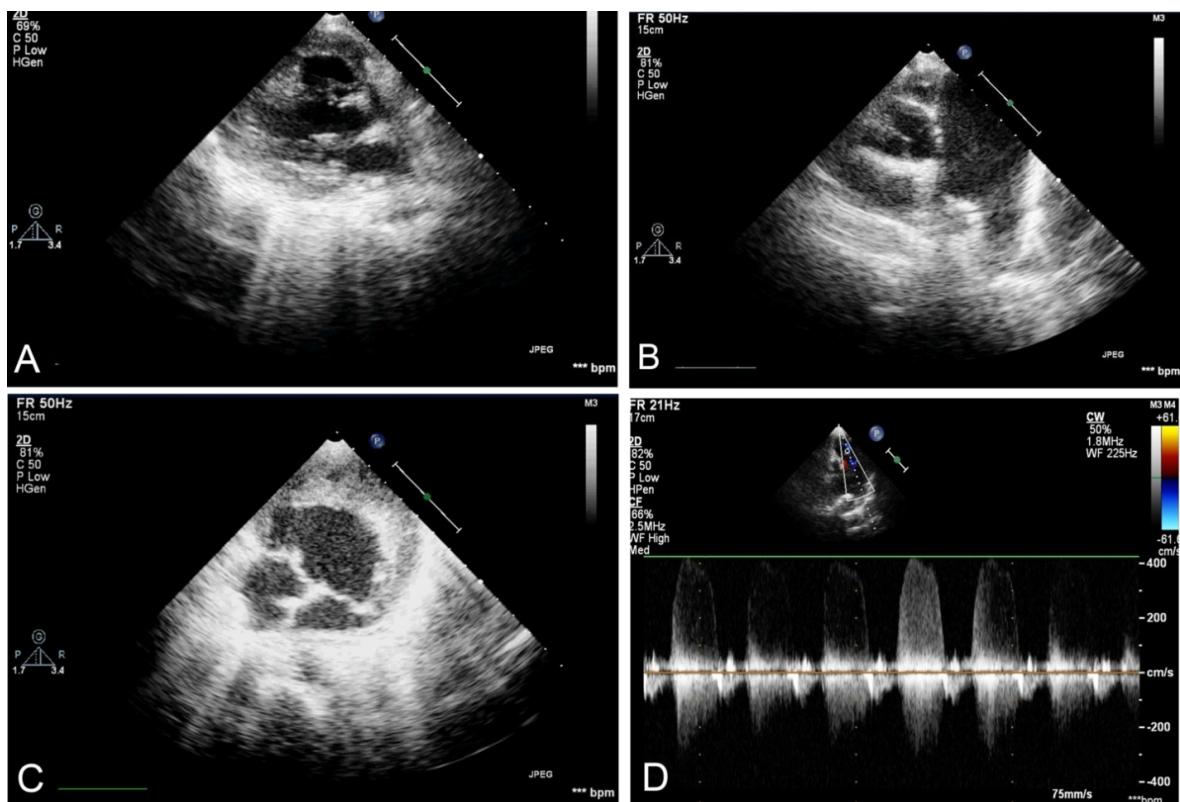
2D echocardiography showing hypertrophy of left ventricle (A) Morphological left ventricle with rudimentary right ventricle (B) Normally related great vessels (C) Opening of both atrioventricular valves in single ventricle (D) Dilated pulmonary artery with moderate-to-severe pulmonary regurgitation.
